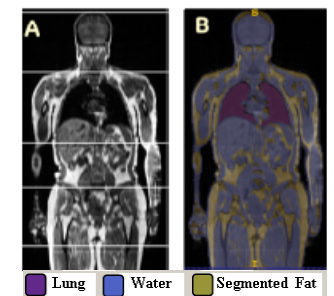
(a) Stitched whole body in-phase image with anatomy localization; (b) 4-class segmented MR image
